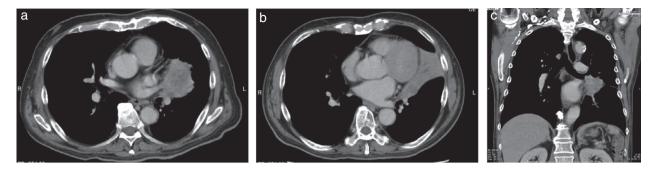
(a–c) Chest computed tomography examination at pretreatment. A $55 \times 40 \times 45$ -mm tumor was found in the lingular segment, and pericardial infiltration was suspected.
